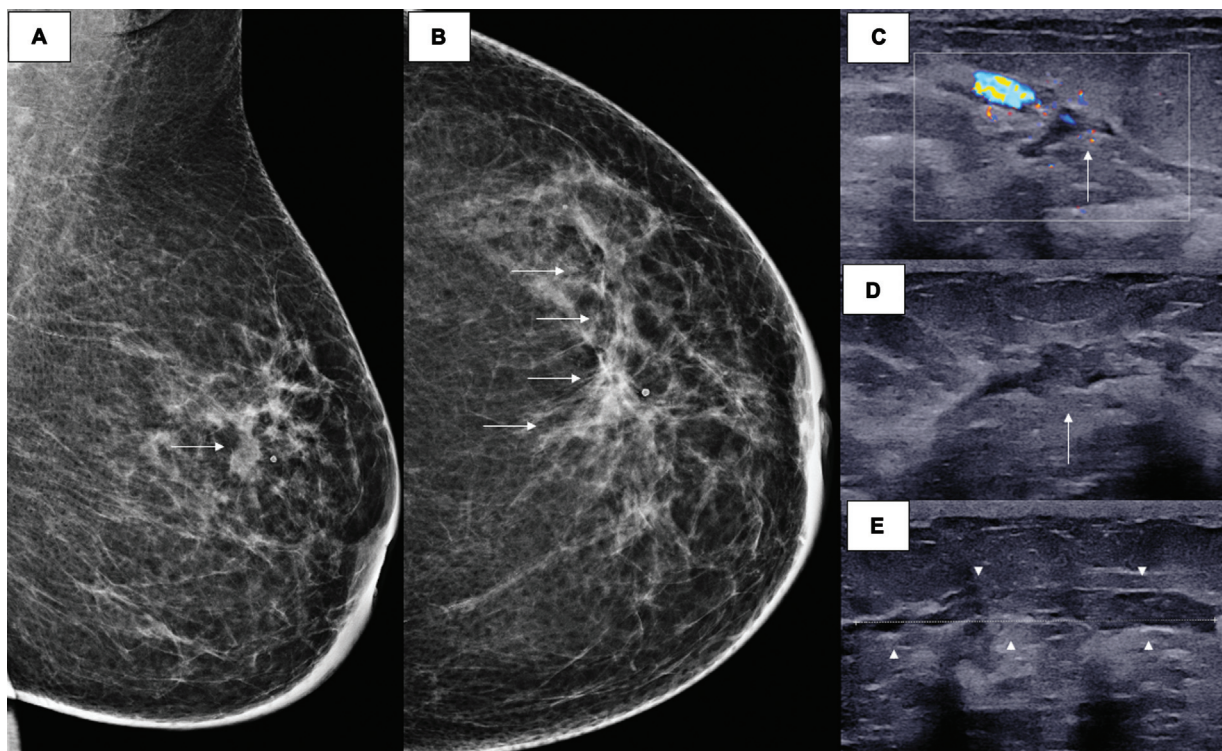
Residual lesion postchemotherapy. Mediolateral oblique and craniocaudal views showing a focal asymmetry with architectural distortion, seen extending along the upper outer quadrant (white arrows in A & B) corresponding to the previous site of the mass. A careful second look ultrasound revealed a nonmass hypoechoic lesion with surrounding architectural distortion and internal vascularity (white arrows in C & D, arrowheads in E).
